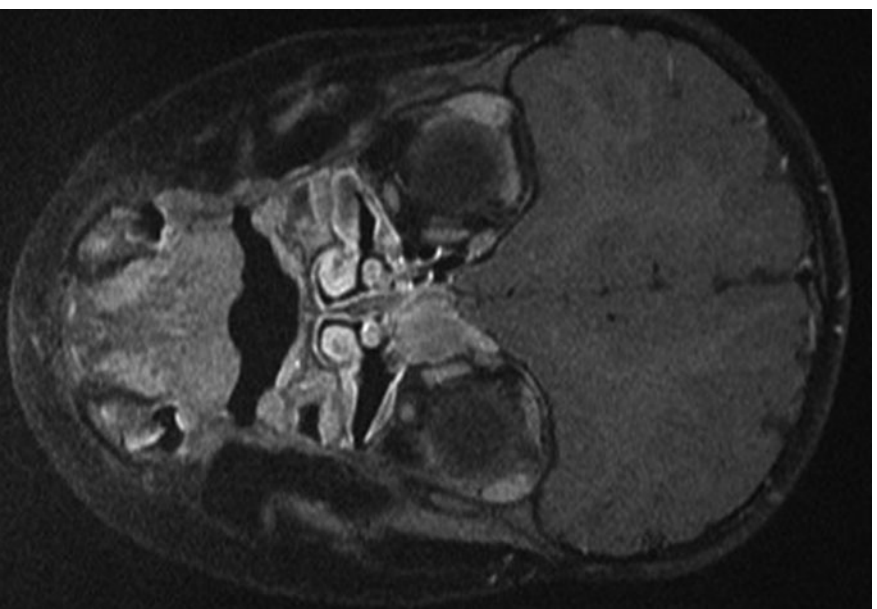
Pre-operative coronal plane magnetic resonance image for patient 1.
